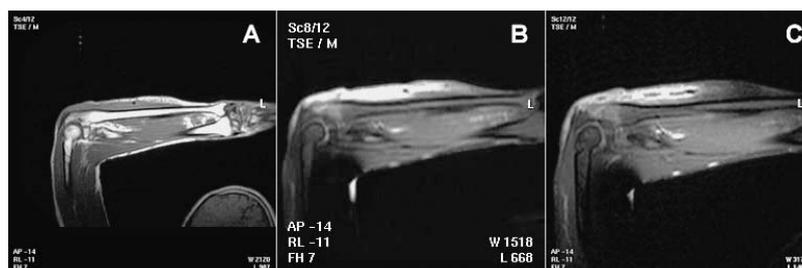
(A) A T1-weighted sagittal MRI reveals subcutaneous inflamed tissue as isointense to the subjacent muscles. The neighboring ulna were preserved, including its cortical integrity. (B) A T2-weighted sagittal MRI shows the intense edema of the subcutaneous tissue as a highlighted area (hyperintense with respect to the subjacent muscles). (C) A post-contrast (gadolinium) T1-weighted sagittal MRI with fat suppression shows heterogeneous enhancement of the diseased subcutaneous tissue, indicating co-existing inflammation with edema.
